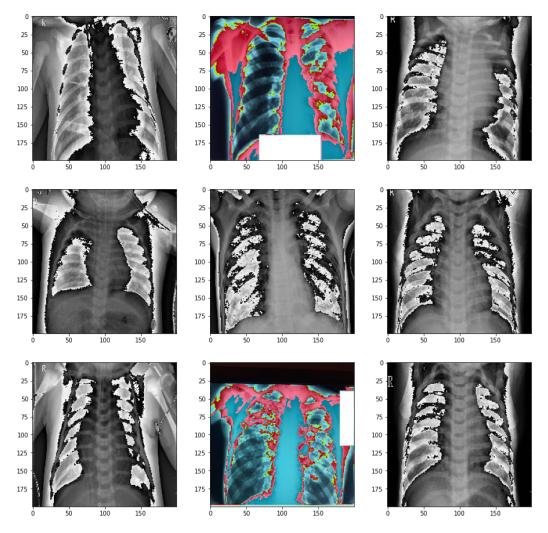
Generated Augmented Pediatric Chest-X-ray Images
